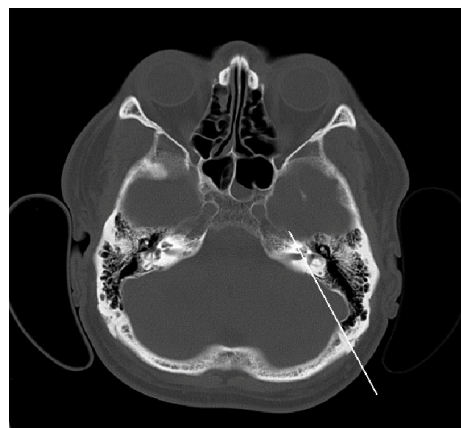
CT bone window depicting dangerous anatomical structures while drilling IAC in case 2
